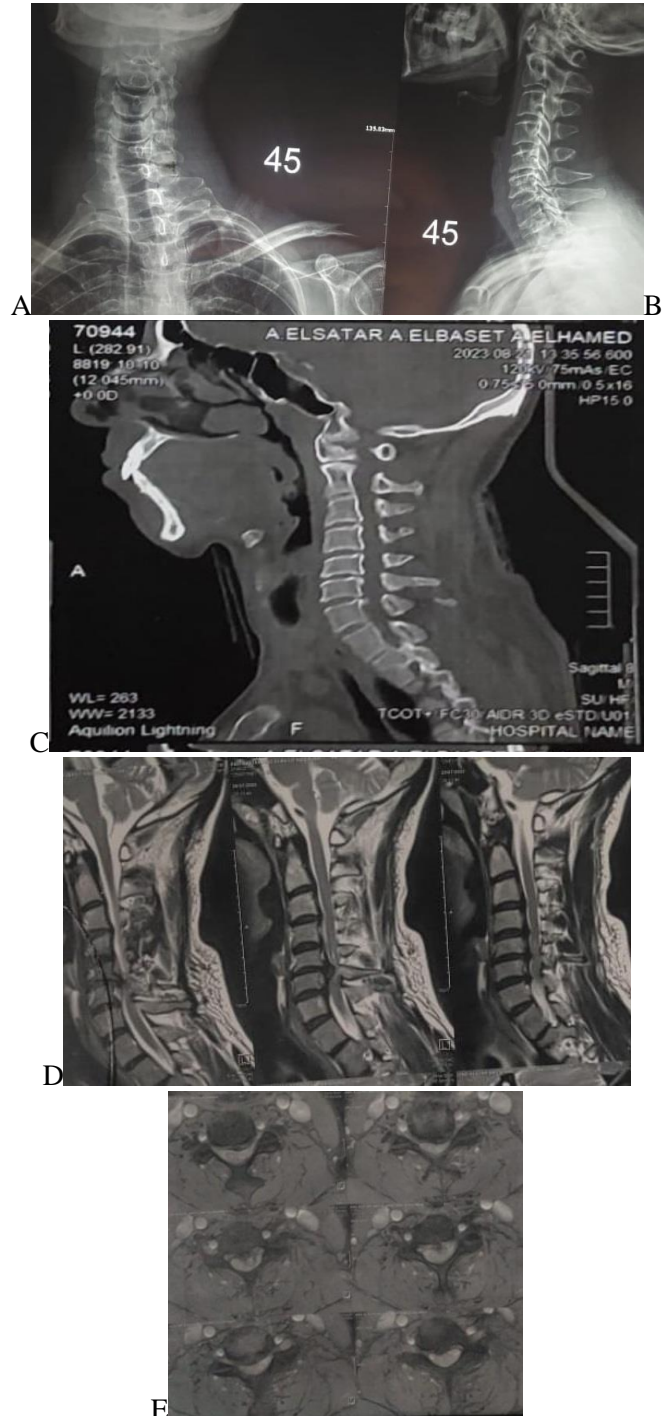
Preoperative X-ray: (A) AP view and Lateral view showing kyphotic sagittal alignment with narrowing of disc spaces C4-5, C5-6, C6-7, (C) CT scan show posterior osteophytes (D, E) MRI: Sagittal and axial views showing C4-5&C5-6 &C6-7 disc prolapses.
